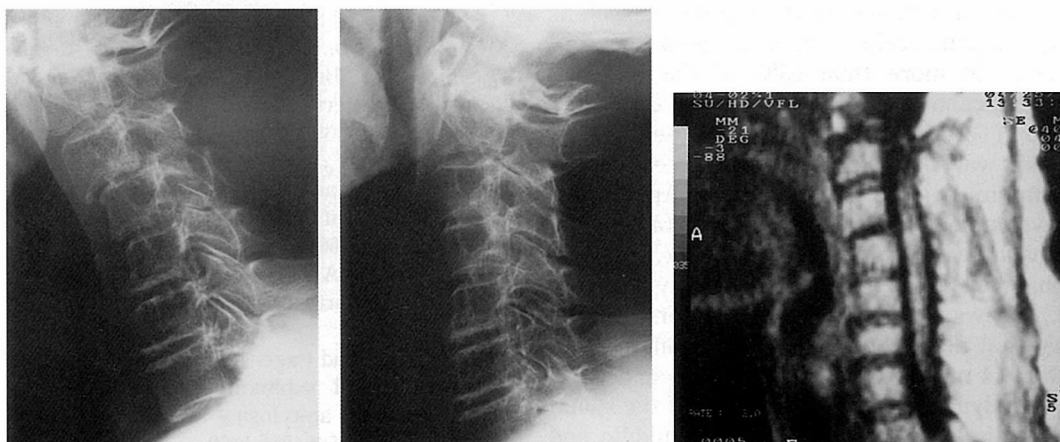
A case of myelopathy. In this case, anterior subluxation of C3 is seen and MR imaging reveals the cord compression.
